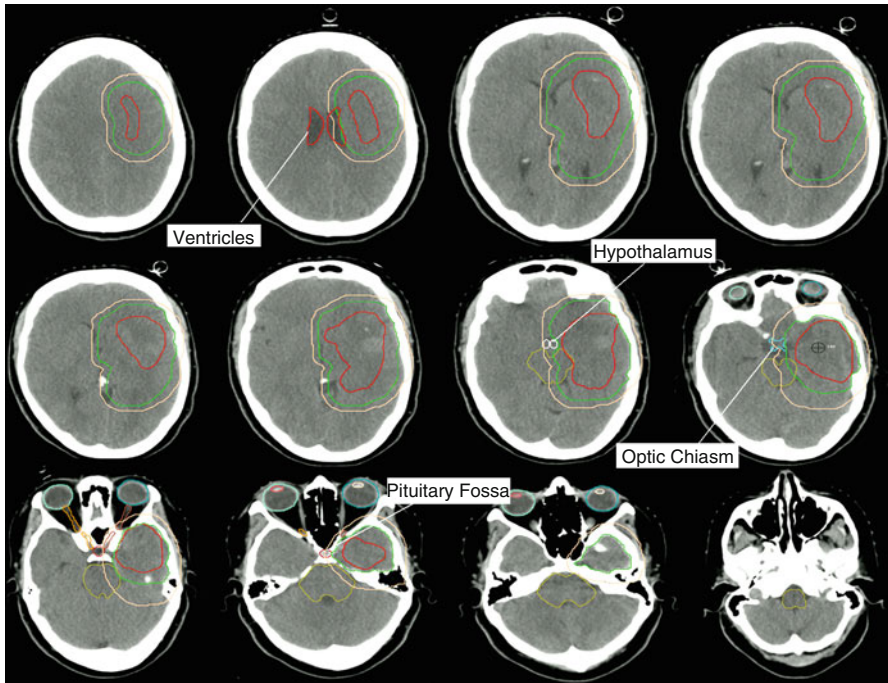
Low-grade glioma, outlined on planning CT according to visible abnormality seen on T2-weighted MRI sequence
